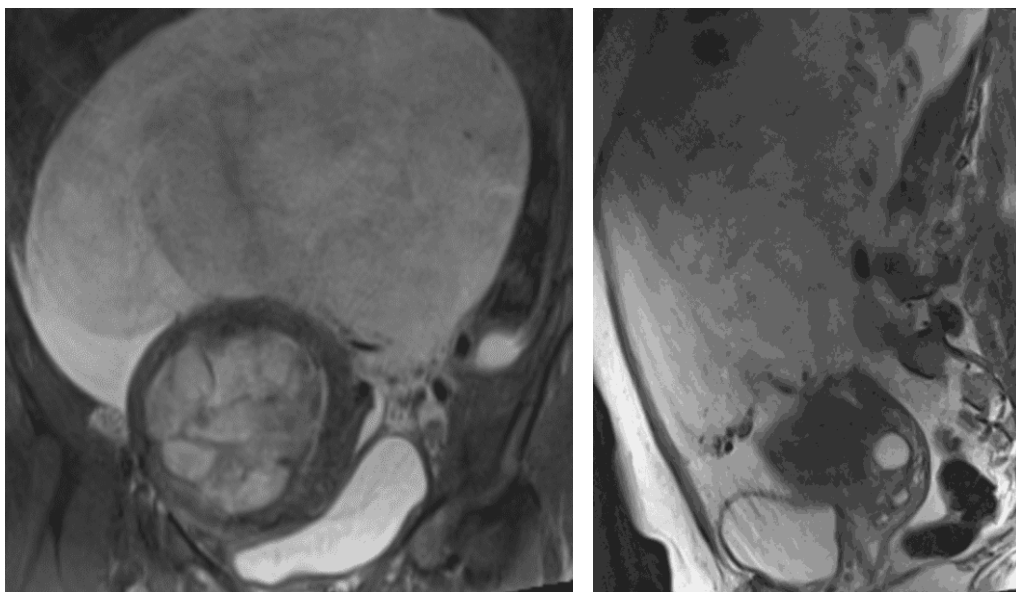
Coronal and sagittal T2-weighted images demonstrating a heterogeneous predominantly hyperintense mass extending superiorly to the L2 vertebral level with peripheral displacement of bowel loops.
